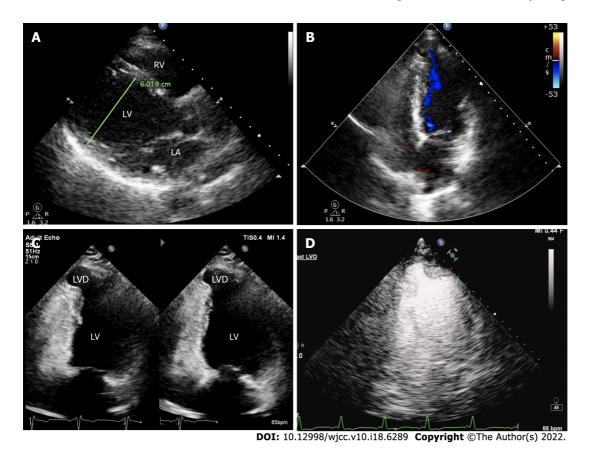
Transthoracic echocardiography results of the patient under this study. A: Long-axis view of the left ventricle at the end of diastole. The left ventricle was dilated with a diameter of 60 mm; B: Cystic outpouching in the left ventricular apical septum on the apical four-chamber view and intra-cystic blood flow signals were seen during systole; C: Cystic outpouching had an approximate size of 12 mm × 13 mm with a continuous muscle wall, while its activity synchronized with ventricular contraction and diastole; D: Myocardial contrast echocardiograph revealed no obvious filling defect in the cystic structure.
